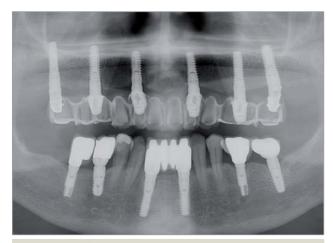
X-ray after 59 months in situ.
